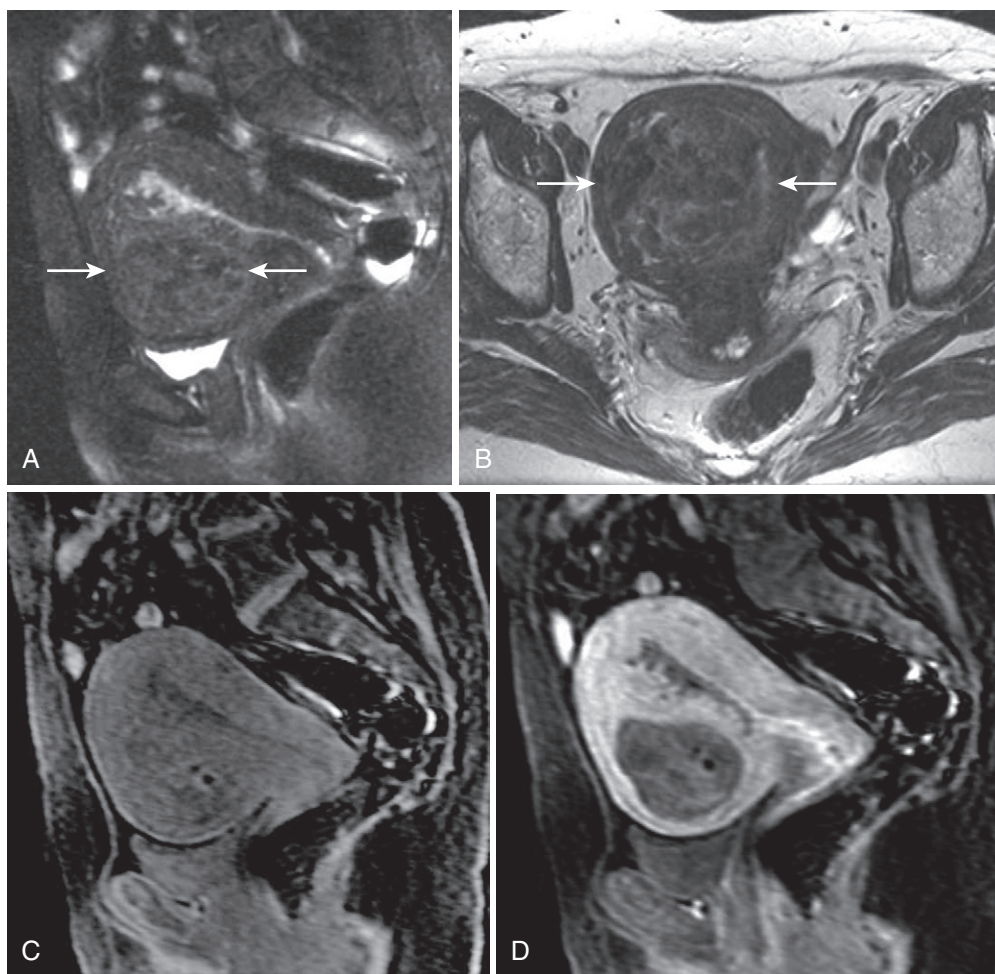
Endometrial carcinoma with myometrial invasion. Sagittal (A) and axial (B) T2-weighted images show a heterogeneous mass (*arrows*) centered in the anterior myometrium nearly reaching the serosal surface indicating deep myometrial invasion. Sagittal pregadolinium (C) and postgadolinium (D) T1-weighted fat saturated gradient echo images show marked lesion hypovascularity compared with enhancing myometrium (which exceeds the more commonly observed milder hypovascularity). The enhanced image vividly portrays the deep myometrial invasion (predicting distant metastatic spread).
